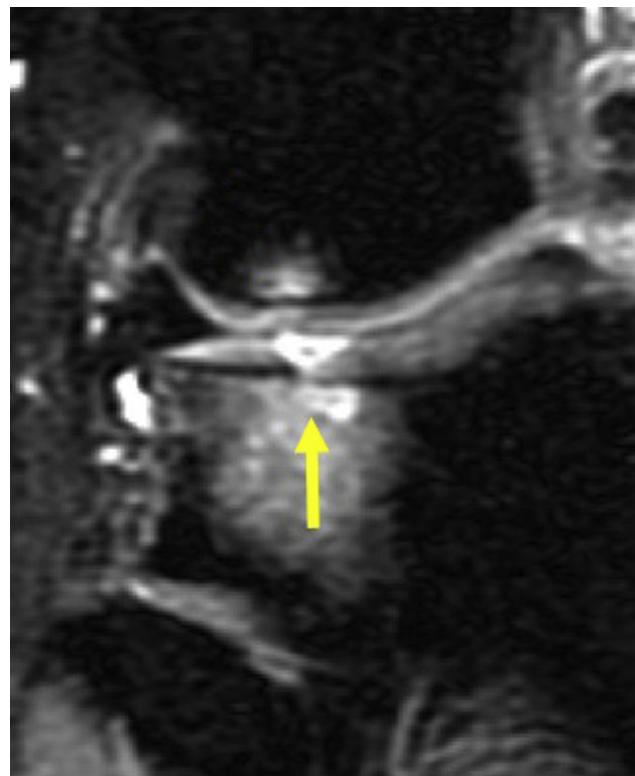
Magnetic resonance image of tibial plateau 11 months after microfracture confirms subchondral lucency (arrow) caused by subchondral cyst formation. (Courtesy of Carl S. Winalski, M.D.)
